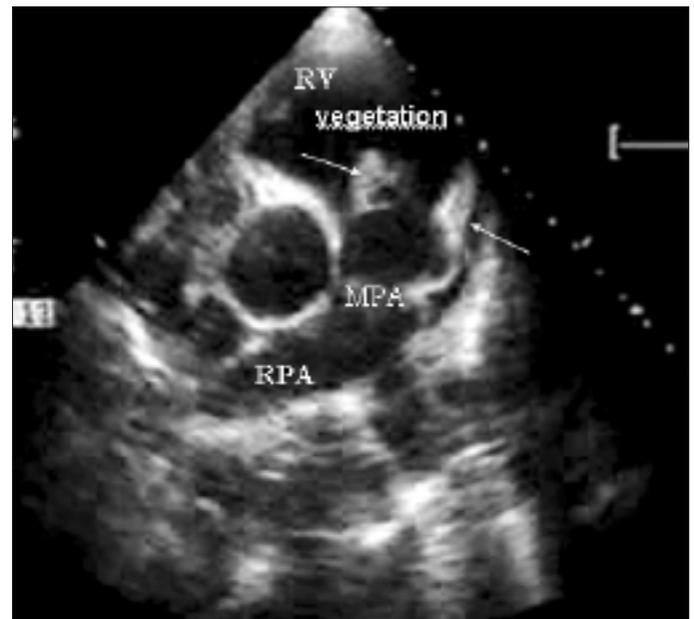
Transthoracic echocardiography view of mobile mass adherent to ventricular aspects of pulmonic valve during diastole
